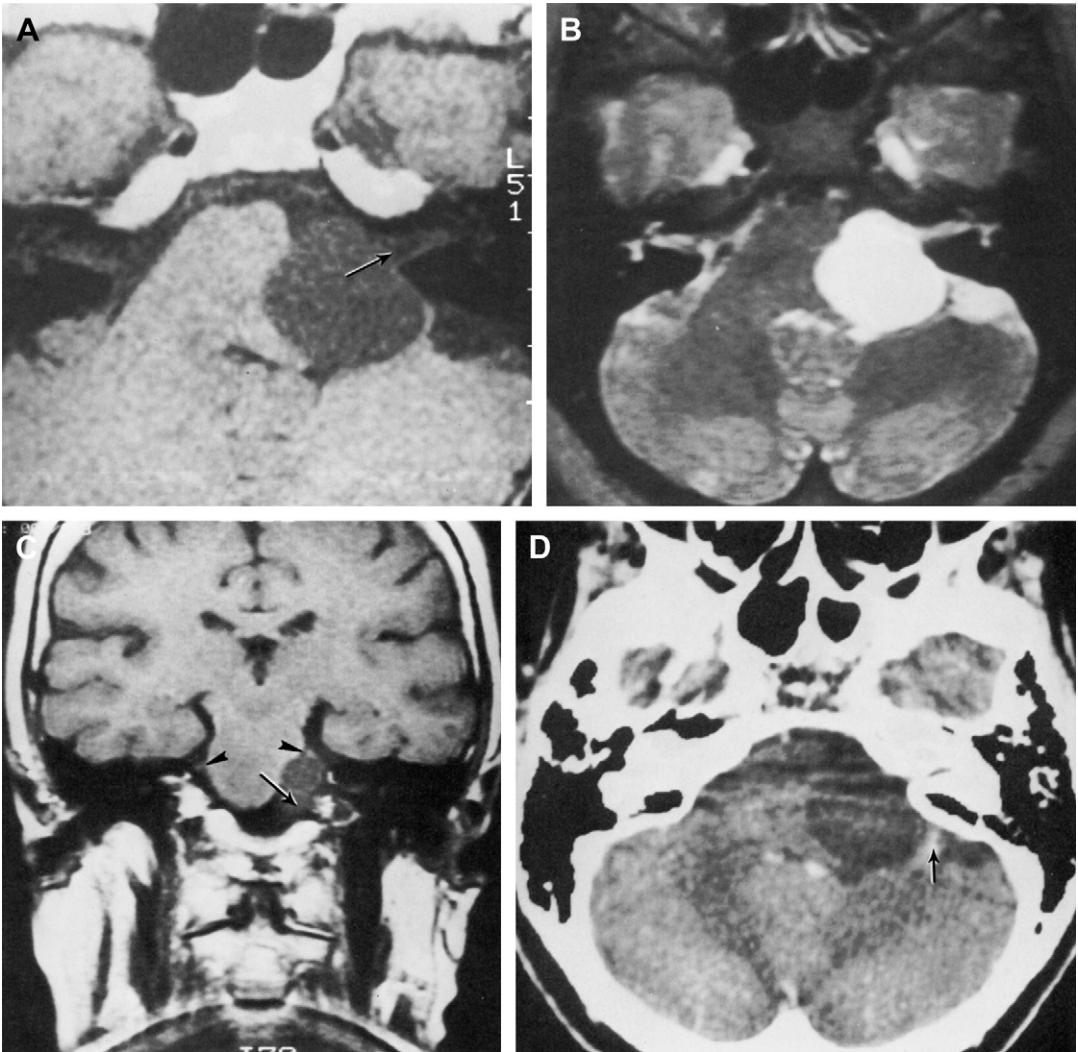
Cystic neurilemoma of CPA cistern. Lesion probably arising from the glossopharyngeal nerve. (A) T₁-weighted image (no gadolinium). The lesion is seen in the CPA cistern pushing the brain stem and pons toward the right. The lesion protrudes into the porus but does not fill the internal auditory canal. Edge of lesion (arrow). (B) T₂-weighted image shows high signal in the apparently cystic abnormality. (C) Coronal T₁-weighted image. The lesion could be followed to the pars nervosa inferiorly (arrow). The lesion pushed the trigeminal nerve (arrowhead on right) superiorly. Compare with trigeminal nerve on the opposite side (arrowhead). (D) Axial computed tomography scan post-contrast. Petrosal vein tributaries are pushed posteriorly (arrow) and the lesion does not enhance. This lesion was attached to the glossopharyngeal nerve at surgery.
